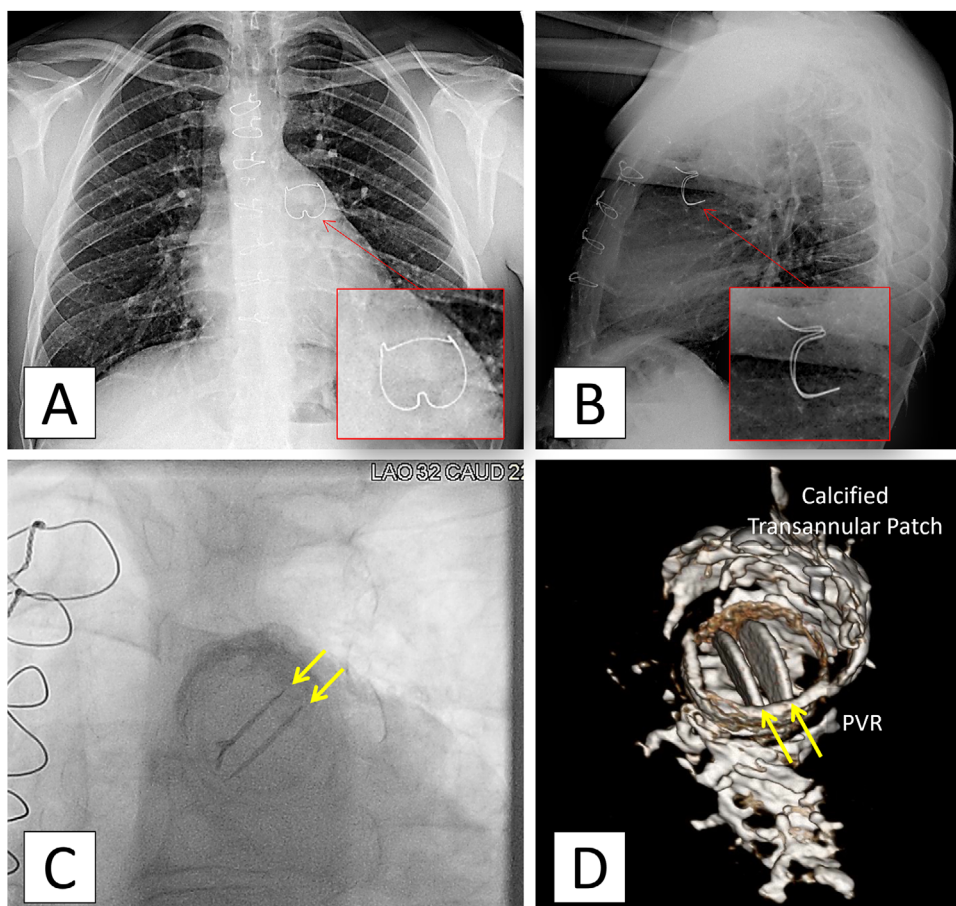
Surgical pulmonic valve replacements Panels A and B: Biological pulmonary valve in a repaired TOF patient. Panel C: Fluoroscopy of a bileaflet mechanical pulmonary valve with normal leaflet position. Panel D: 3D CT of a St. Jude mechanical valve with calcified leaflets and transannular patch calcification (see Figure 6 for details).
